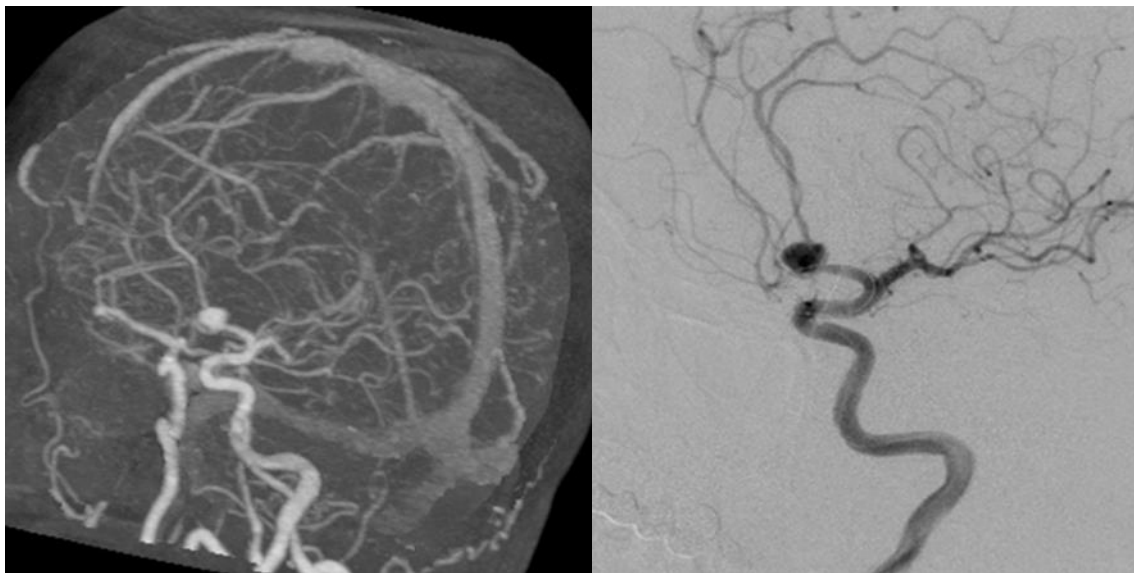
Initial CTA and DSA of right A2 before EVT, 51-year old patient with ruptured aneurism of right anterior communicant artery, treated with IV Nimodipine from admission, there is no relaxation of vasospasm
